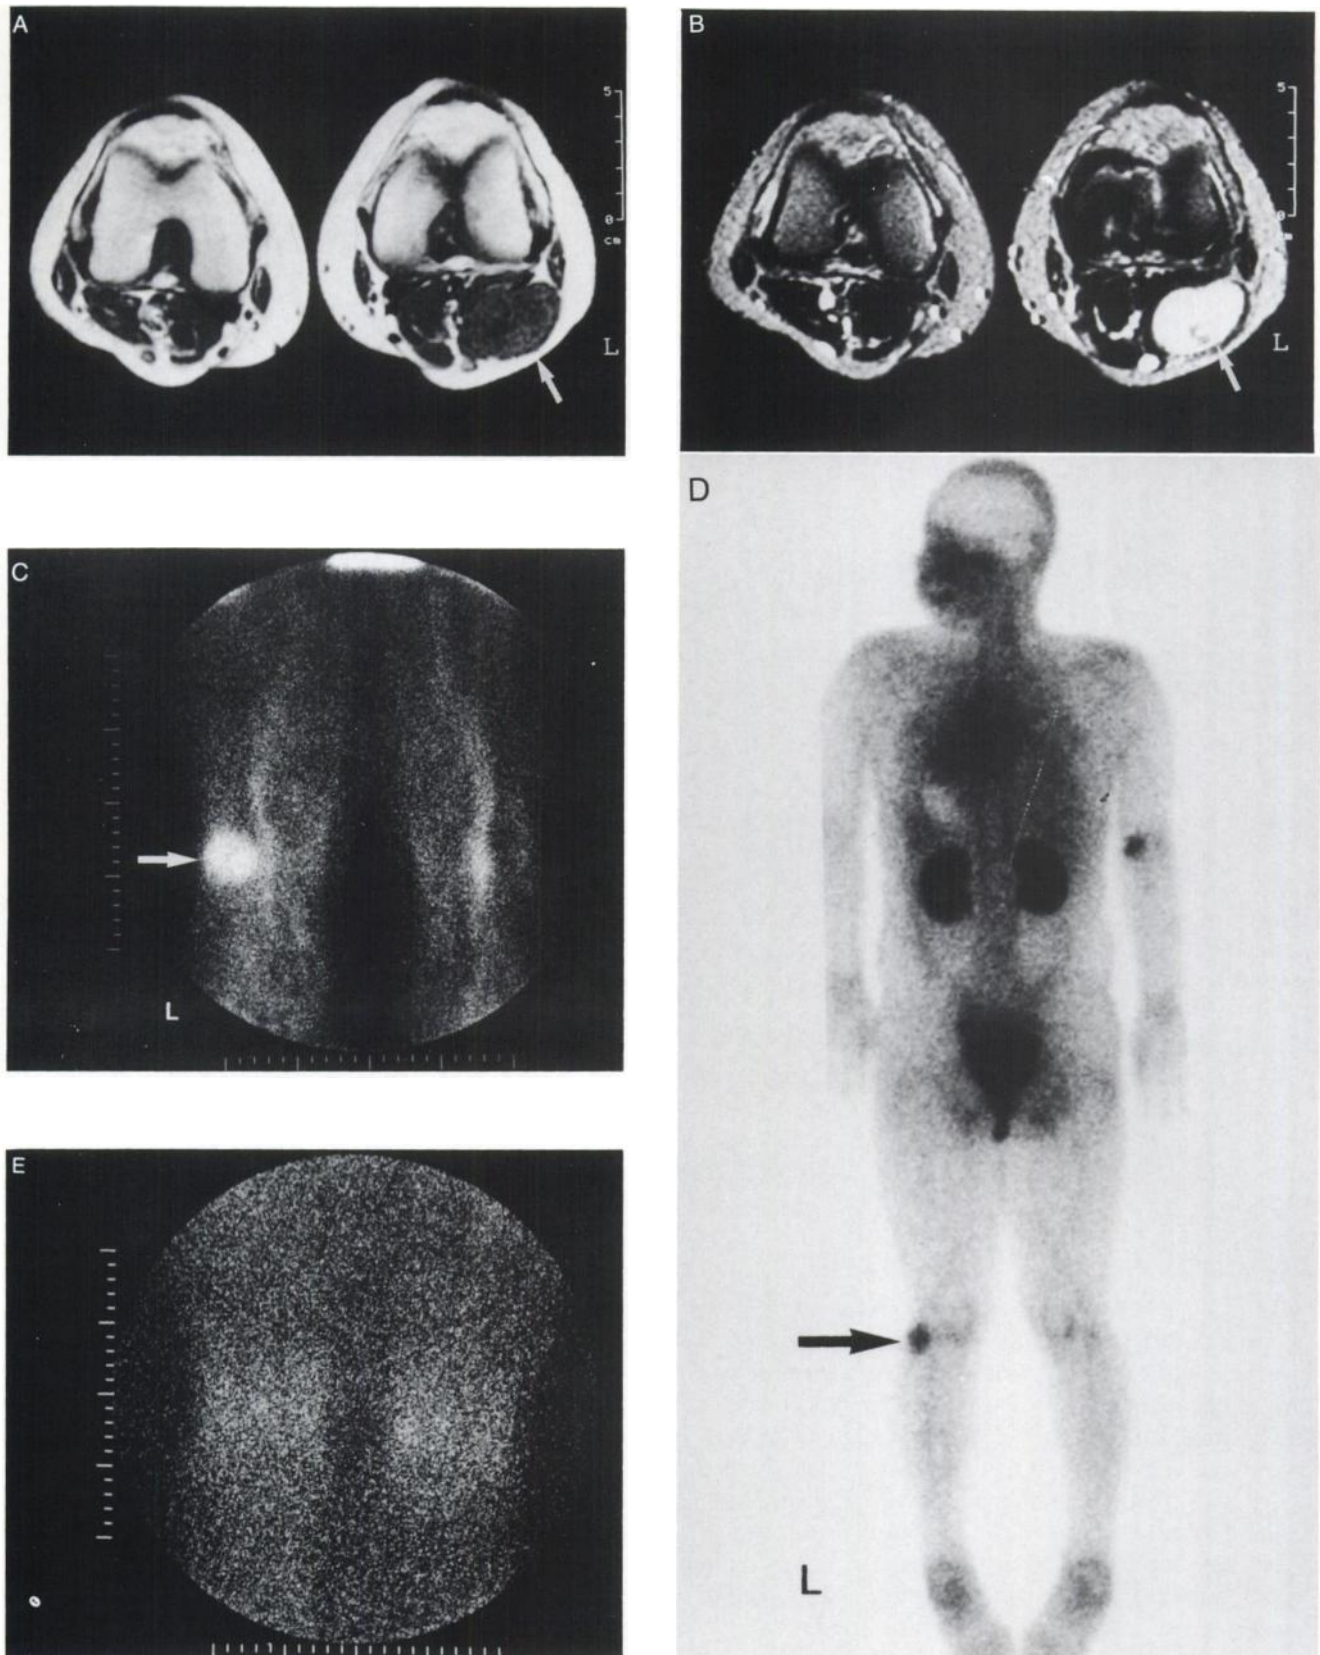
(A) T1-weighted MRI in a 45-yr-old woman (Patient 1). A well-defined oval tumor (arrow) that is isointense to the adjacent skeletal muscle is present in the left popliteal fossa. (L = left). (B) T2-weighted MRI reveals that the tumor (arrow) is markedly hyperintense to subcutaneous fat. (C) A posterior spot $^{99m}\text{Tc}(\text{V})\text{DMSA}$ scintigram shows marked accumulation in the tumor (arrow). (D) On a posterior whole-body $^{99m}\text{Tc}(\text{V})\text{DMSA}$ scintigram, the tumor in the left popliteal fossa (arrow) can easily be detected. The uptake at right elbow was subcutaneous leakage of the tracer. (E) A posterior spot ^{67}Ga -citrate scintigram in the same patient shows no accumulation in the tumor.
